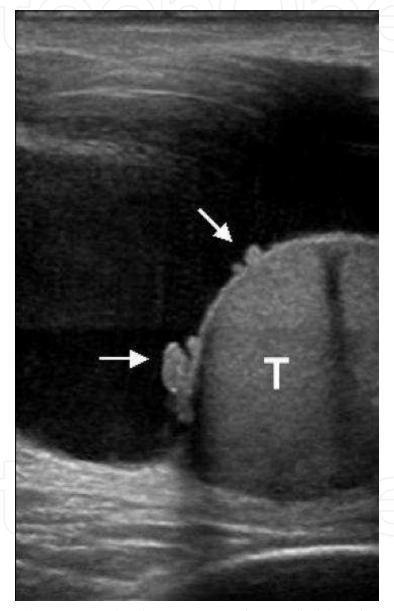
Preoperative ultrasonography demonstrating the testicle (T) and a paratesticular mass (arrows - mesothelioma of the tunica vaginalis testis).
